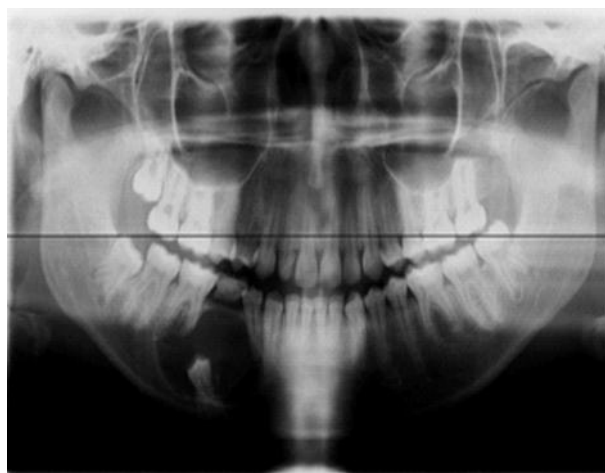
Radiograph of Unilocular cystic ameloblastoma with impacted tooth
